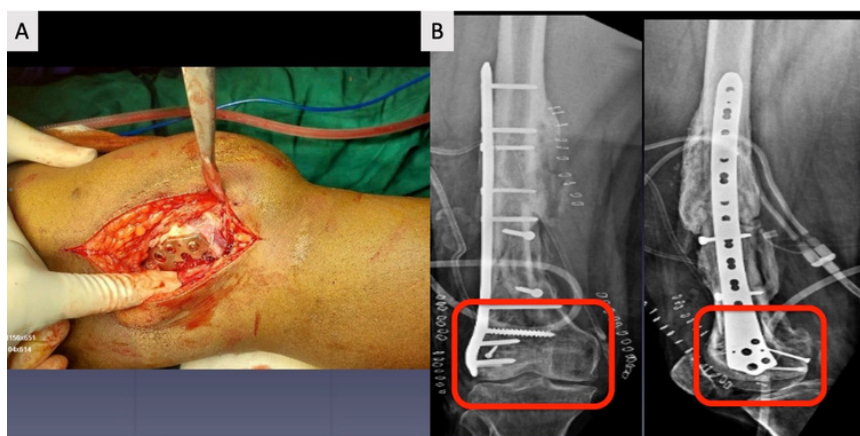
Intraoperative images(A) and Plain Radiographs (B) showing screws of the distal femoral LCP & CC screws that could be a potential hindrance during ligament reconstruction.
